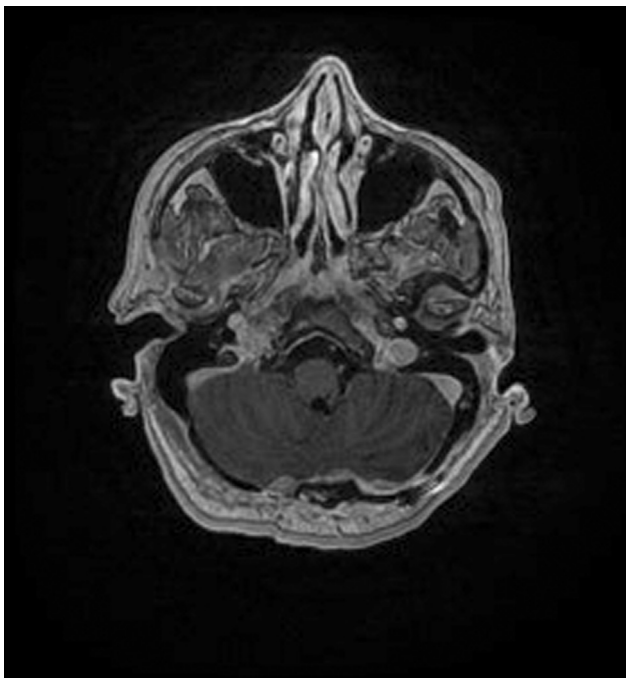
T1 axial-weighted magnetic resonance imaging showing complete resection of the meningioma.
